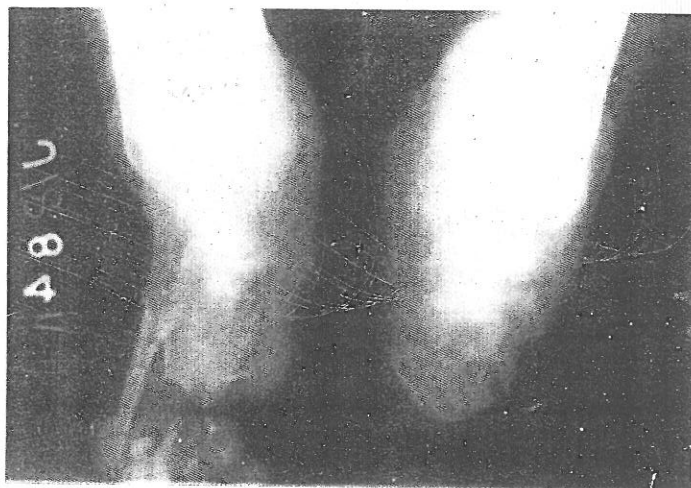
X-ray of feet demonstration complete loss of left forefoot at metatarsals which are disorganised and osteolysis changes of metatarsals and phalanges of right foot in case 4
